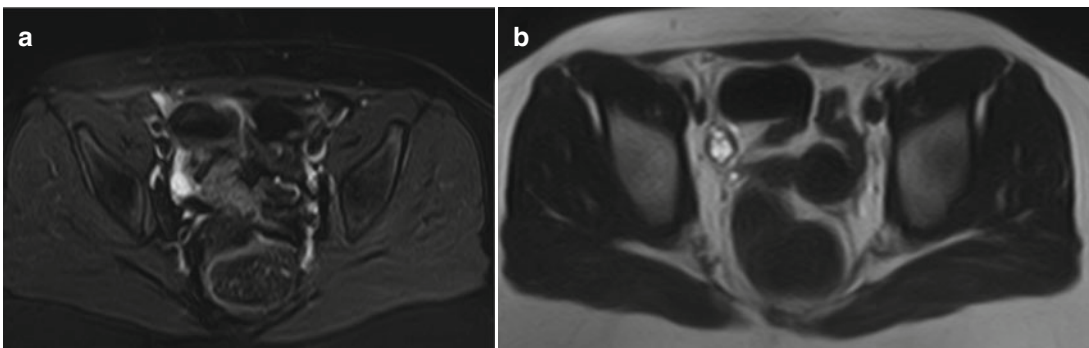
MRI, (a) axial T2-weighted fat-saturated fast SE and (b) axial T2-weighted fast SE demonstrate the internal appendiceal contents hyperintense on the T2-weighted images
